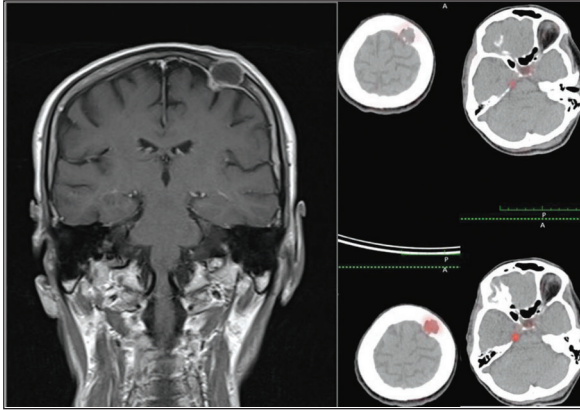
Ga-68 DOTATATE positron emission tomography/computed tomography fusion images showing the brain lesions of the patient in right temporal and left parietal region in the follow up.
